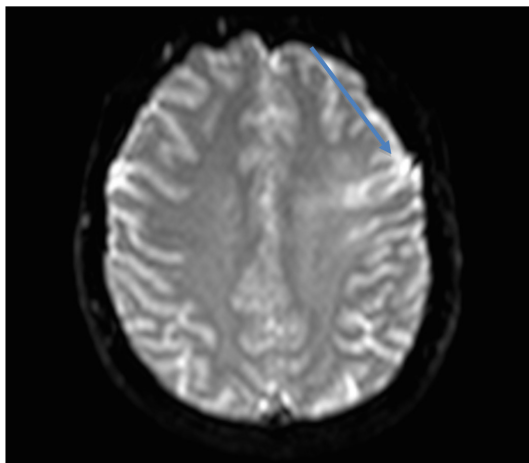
Hyperintense appearance in temporal region T2 sequence in cranial MRI
